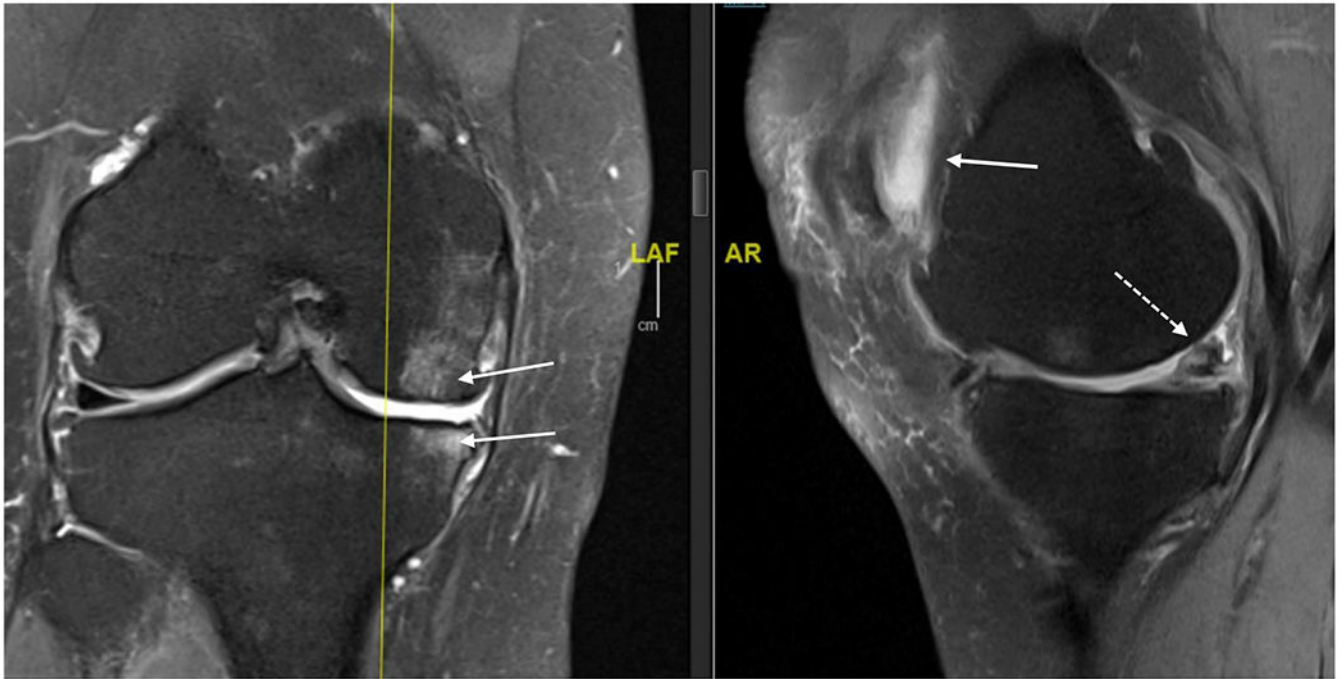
MRI (proton density, fat saturated) of right knee of 63 year old female. Coronal view on left and sagittal view on right. Bone marrow lesions are identified with thin, solid white arrows on the coronal view; meniscal damage and cartilage damage are identified with dashed arrow on sagittal view and retropatellar effusion as solid arrow on sagittal view.
